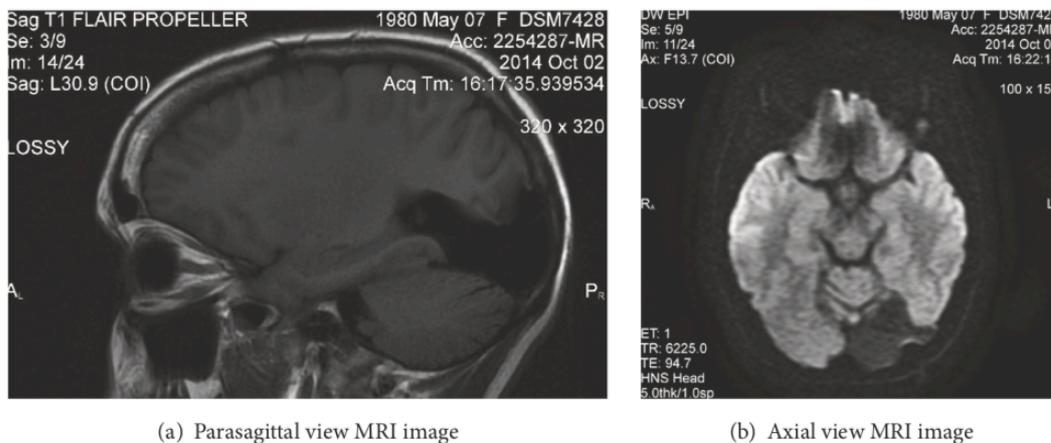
(a) Parasagittal and (b) axial T2 weighted MRI images of the patient's brain after removal of her left occipital arteriovenous malformation
